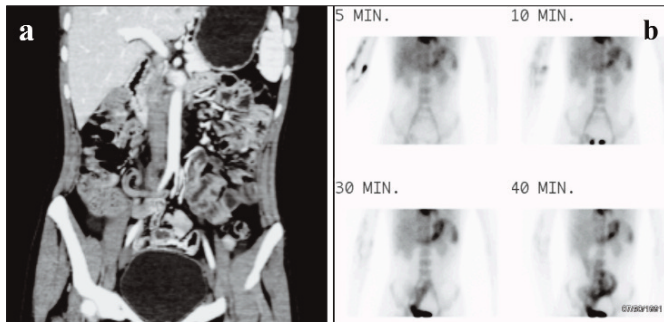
(a) Coronal reformatted image of contrast enhanced CT scan demonstrated abnormal blind ended bowel loop in hypogastric region with enhancing walls. (b) Subsequent pertechnetate scan showed abnormal tracer accumulation in the hypogastric region.
